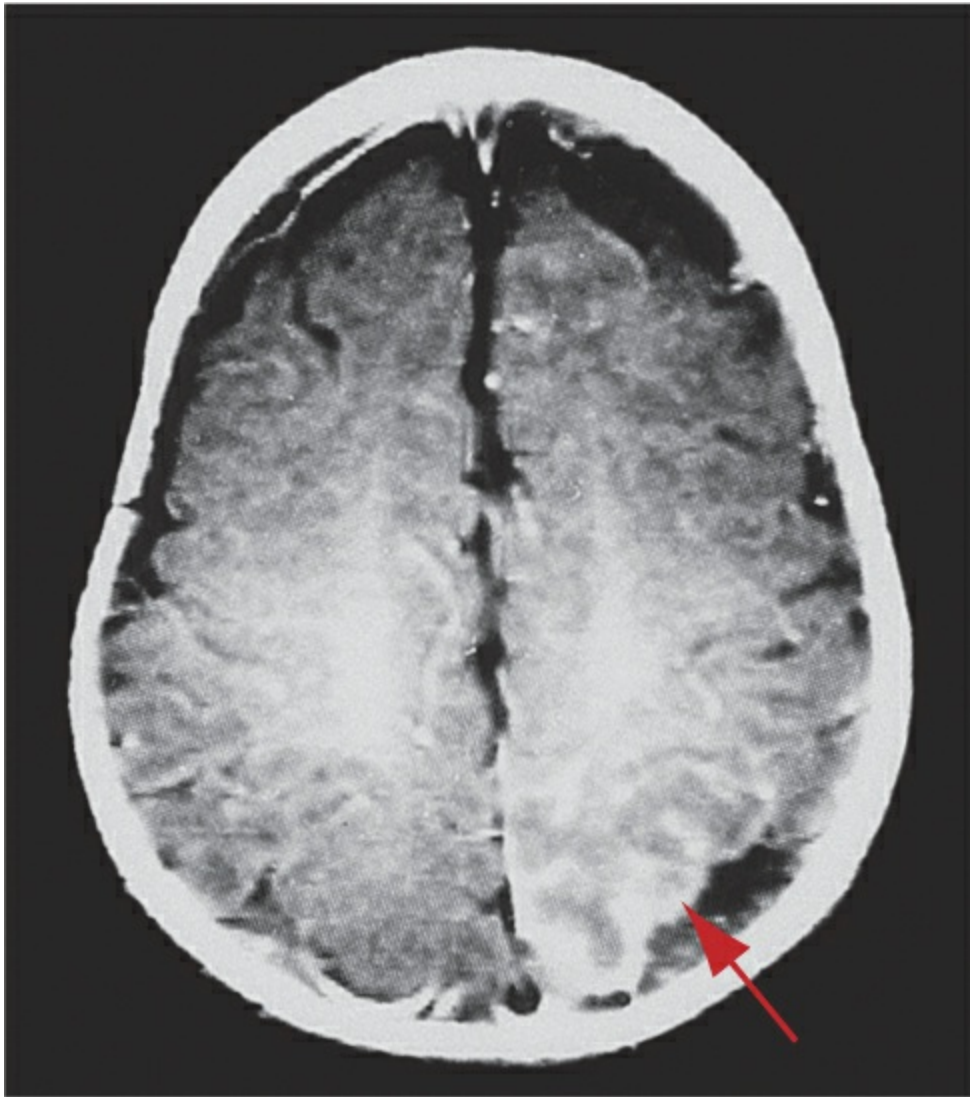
Axial gadolinium-enhanced T1-weighted MR image shows vascular malformation with underlying cortical atrophy (*arrow*) in the left occipital lobe of a 4-month-old girl with Sturge-Weber syndrome.
